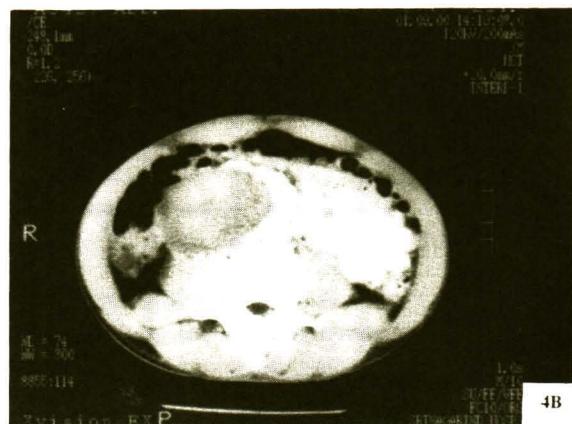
Enhanced CT scans demonstrates non-enhanced hematoma on arterial phase.
